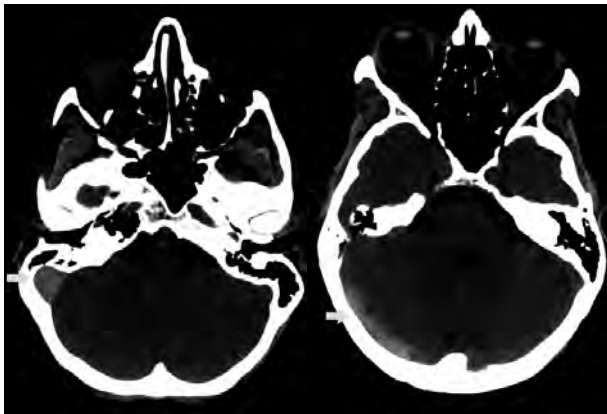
Cranial CT showing a hyperdense image at the sigmoid venous (arrow) and right transverse sinus (arrow).
